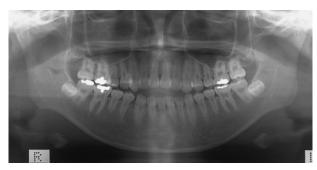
Panoramic radiograph before treatment (13Y7M)
